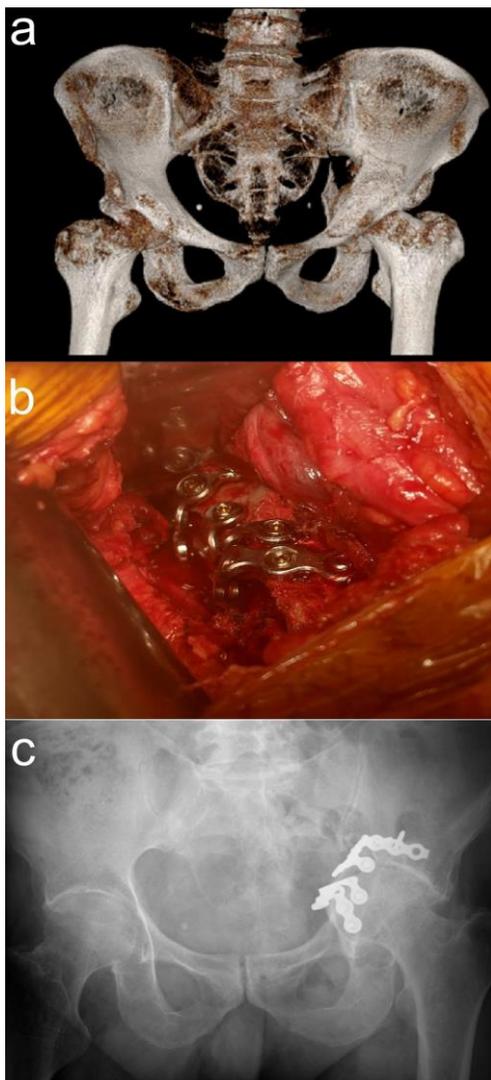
(a) Preoperative 3D computed tomography (CT) imaging of a 71-year-old male patient with an isolated quadrilateral plate fracture of the left hip. (b) Intraoperative image demonstrating medial support of the quadrilateral plate using the spring plate technique. (c) Final follow-up radiograph at 6 years postoperatively.
